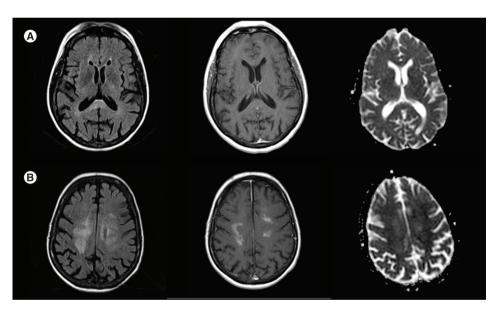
Axial slices from MRI with left: FLAIR, middle: postgadolinium T1; right: apparent diffusion coefficient. (A) MRI on initial presentation demonstrating a T2/FLAIR hyperintense lesion within the splenium that shows some diffusion restriction but does not enhance with contrast. (B) Repeat MRI after 3 months of continued neurologic decline showing the development of T2/FLAIR hyperintensity with patchy enhancement and some diffusion restriction in the bilateral centrum semiovale.
